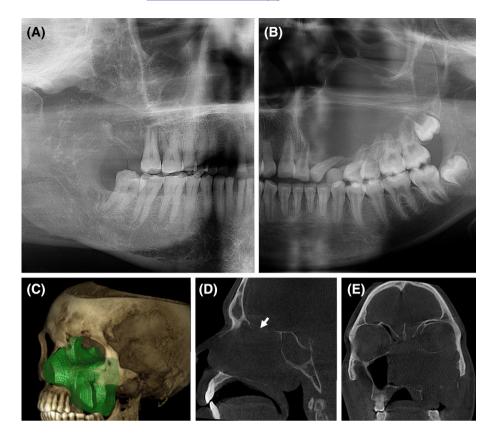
(A) Cropped panoramic radiograph of an AB affecting the posterior maxilla with extension to involve the pterygomaxillary complex. (B) Maxillary AB affecting both the anterior and posterior regions of the left maxilla resulting in the displacement of teeth. the orbit and the nasal cavity. (C) Three-dimensional reconstructed CBCT image showing the extent of a maxillary AB. (D) Sagittal CBCT image showing infiltration of the cranial base (arrow) and sphenoid sinus. (E) Coronal CBCT image showing involvement of the maxillary sinus, nasal cavity and impingement of the medial and inferior borders of the orbit. AB, ameloblastoma; CBCT, cone-beam computerised tomography.
